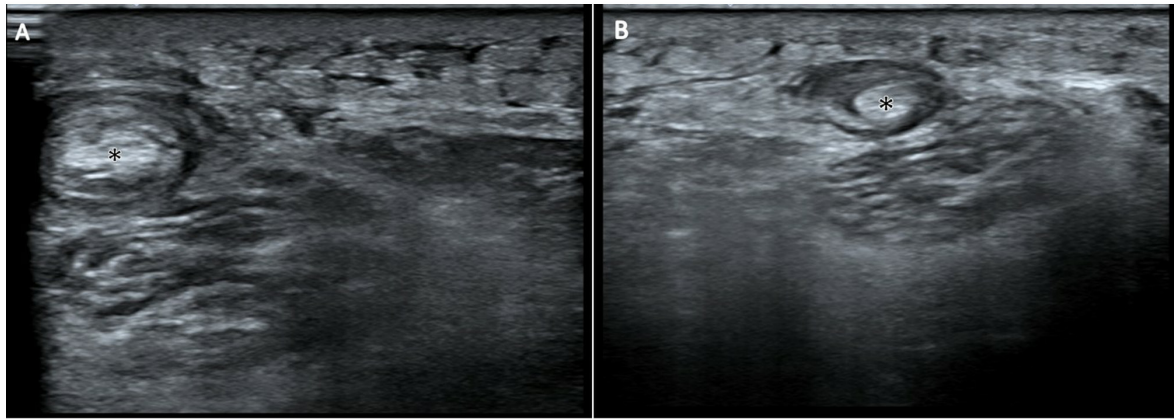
Ultrasonography of the left posterior thigh. (A) Convex array real-time sonography for the subcutaneous layer of the posterior aspect of the left thigh reveals the target appearance with hypoechoic rim and hyperechoic core (black asterisk) over the semimembranosus. (B) In the popliteal fossa of the left knee, there is also a target appearance with hypoechoic rim and hyperechoic core (black asterisk) over the semimembranosus.
